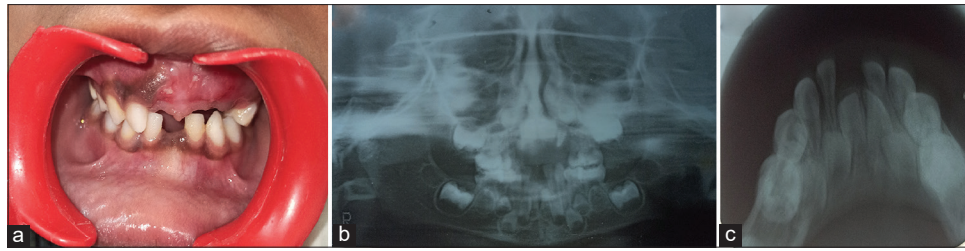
(a) Pre-operative frontal; (b) Preoperative orthopantomogram; (c) Pre-operative mandibular occlusal radiograph
